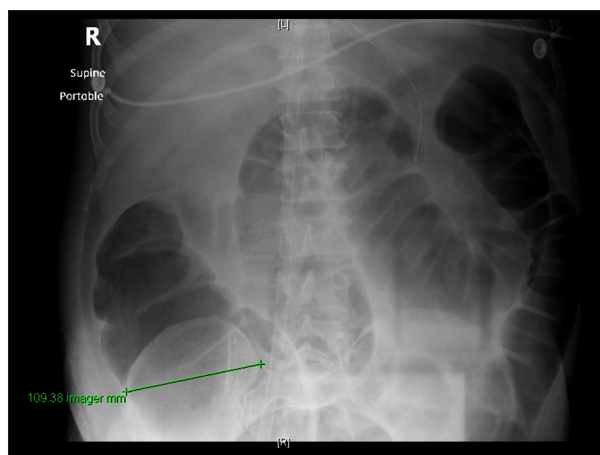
Abdomen X-ray shows colon dilation with cecal diameter about 10.9 cm.
